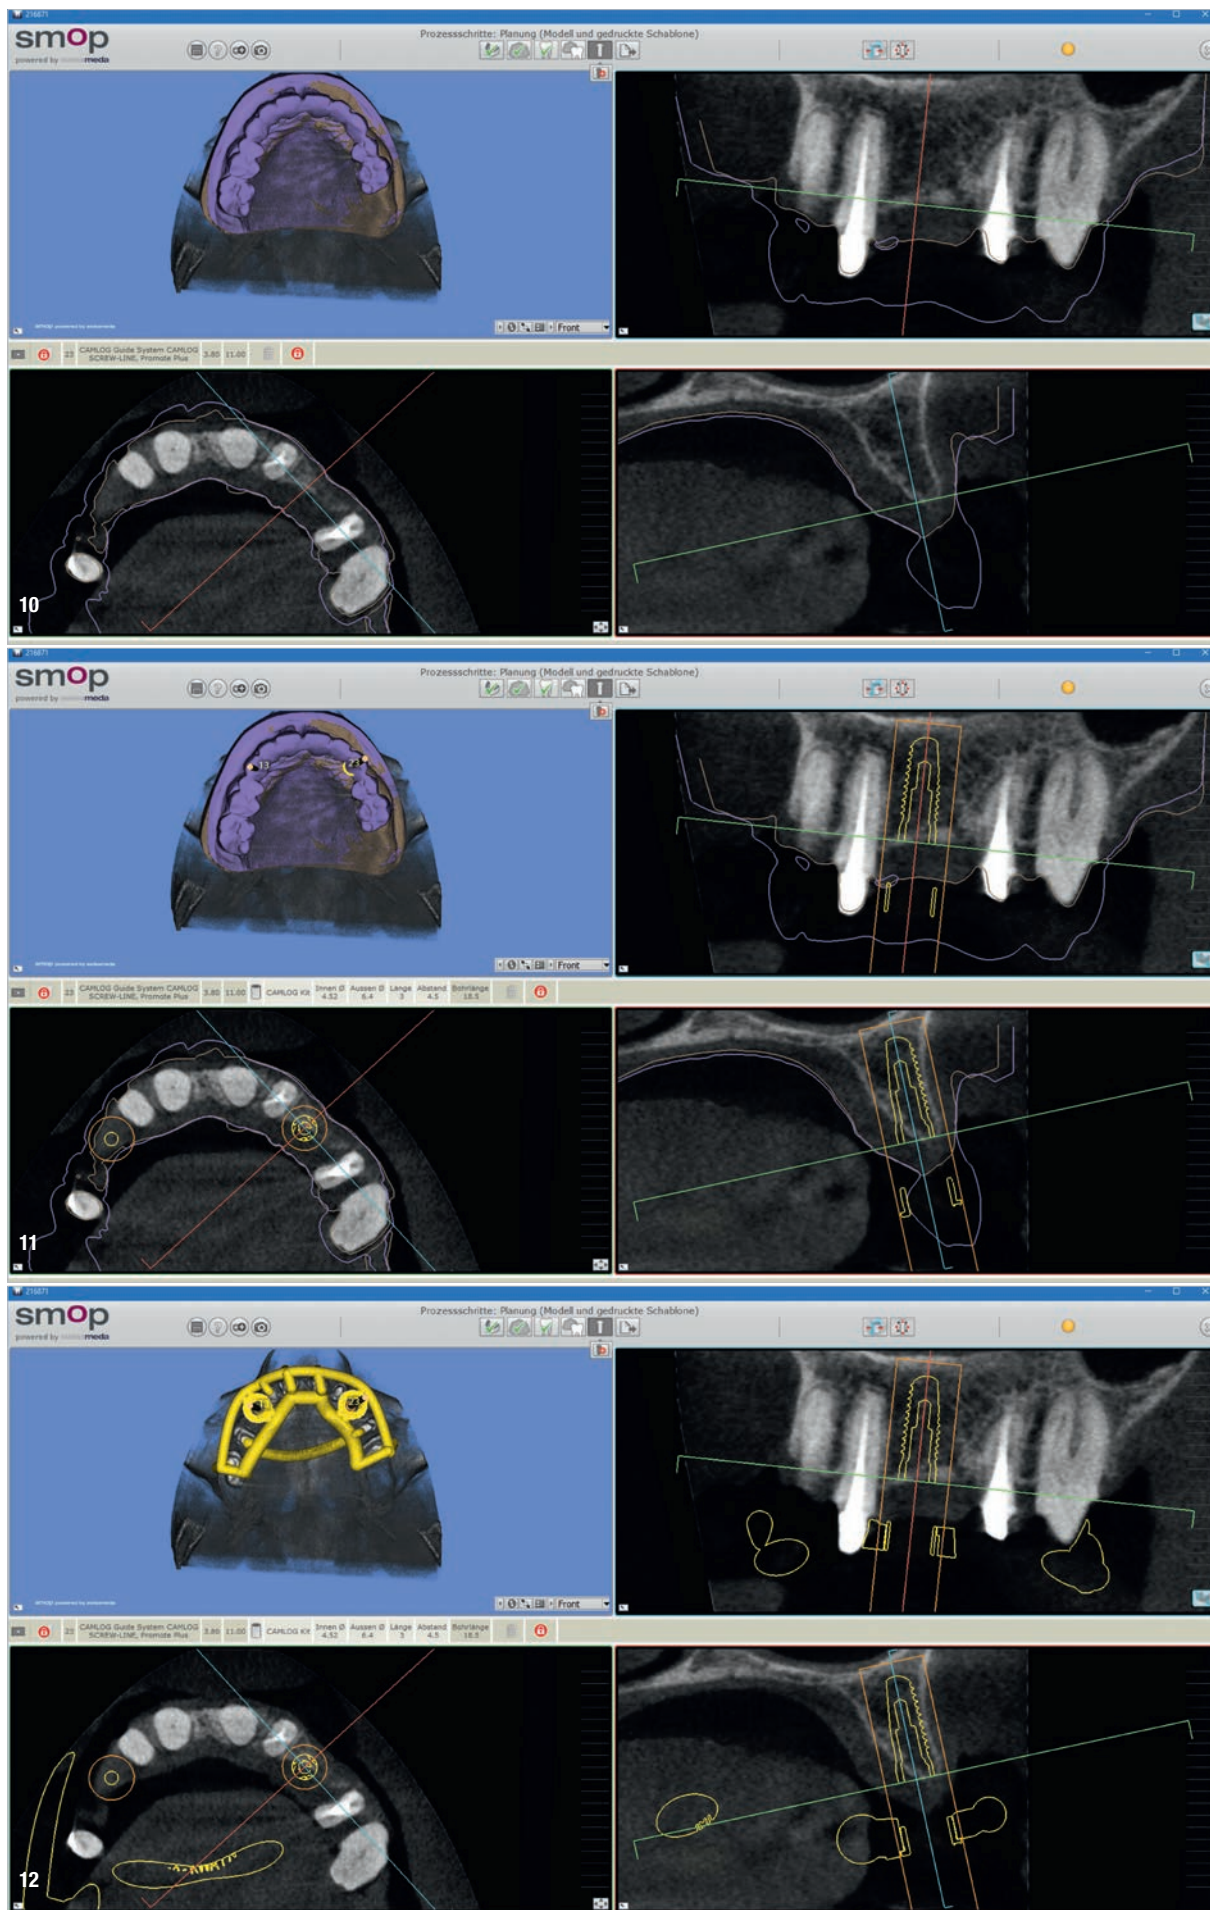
Digital planning of the implant position in region #23 based on the CBCT scan. Fig. 9: CBCT scan matched with the STL data set of the maxillary situation model (displayed in brown). Matching was done by selecting three corresponding points on the CBCT scan and model data sets. Like in this case, fine adjustments by the implantologist are sometimes necessary.
